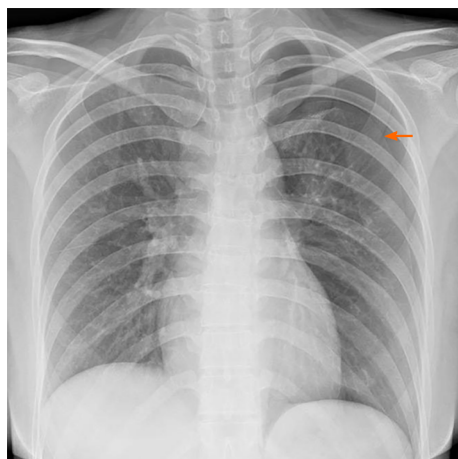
X-ray showing pneumothorax. Patient's chest X-ray showing pneumothorax in the left lung; the lung tissue was compressed to about 30%. The orange arrow represents the pneumothorax line.
